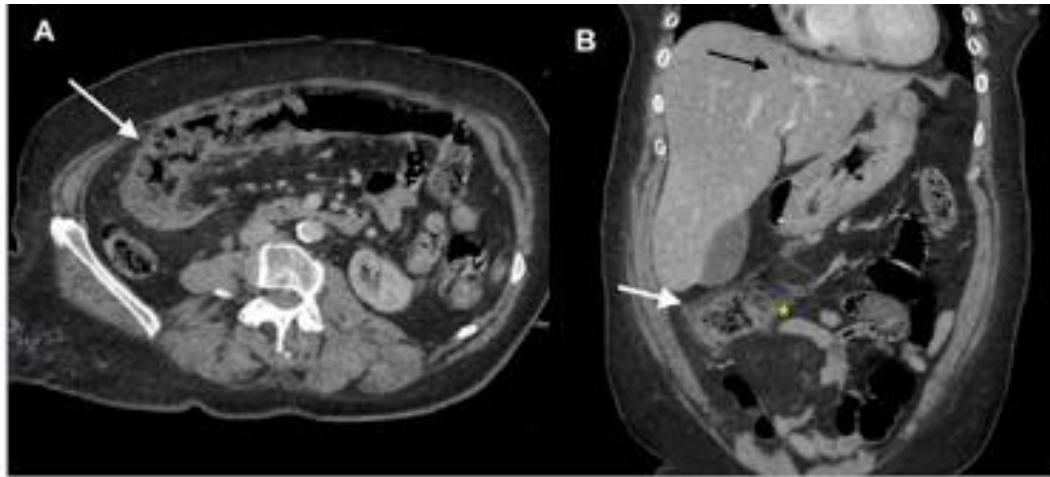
A) Axial contrast-enhanced CT image shows a concentric thickening of the transverse colon and hepatic angle of the colon (white arrow). B) Coronal contrast-enhanced CT image shows intrahepatic portal venous gas (black arrow) and ischemic segments of the colon (white arrow) with local mesenteric fat stranding ().*
